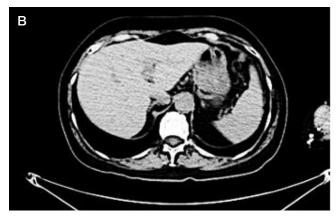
A, B. Abdominal CT, 01.03.2023. Singular metastatic foci (size up to 0.9 cm) in both lobes of the liver; size of the foci decreased compared to 30.11.2022
